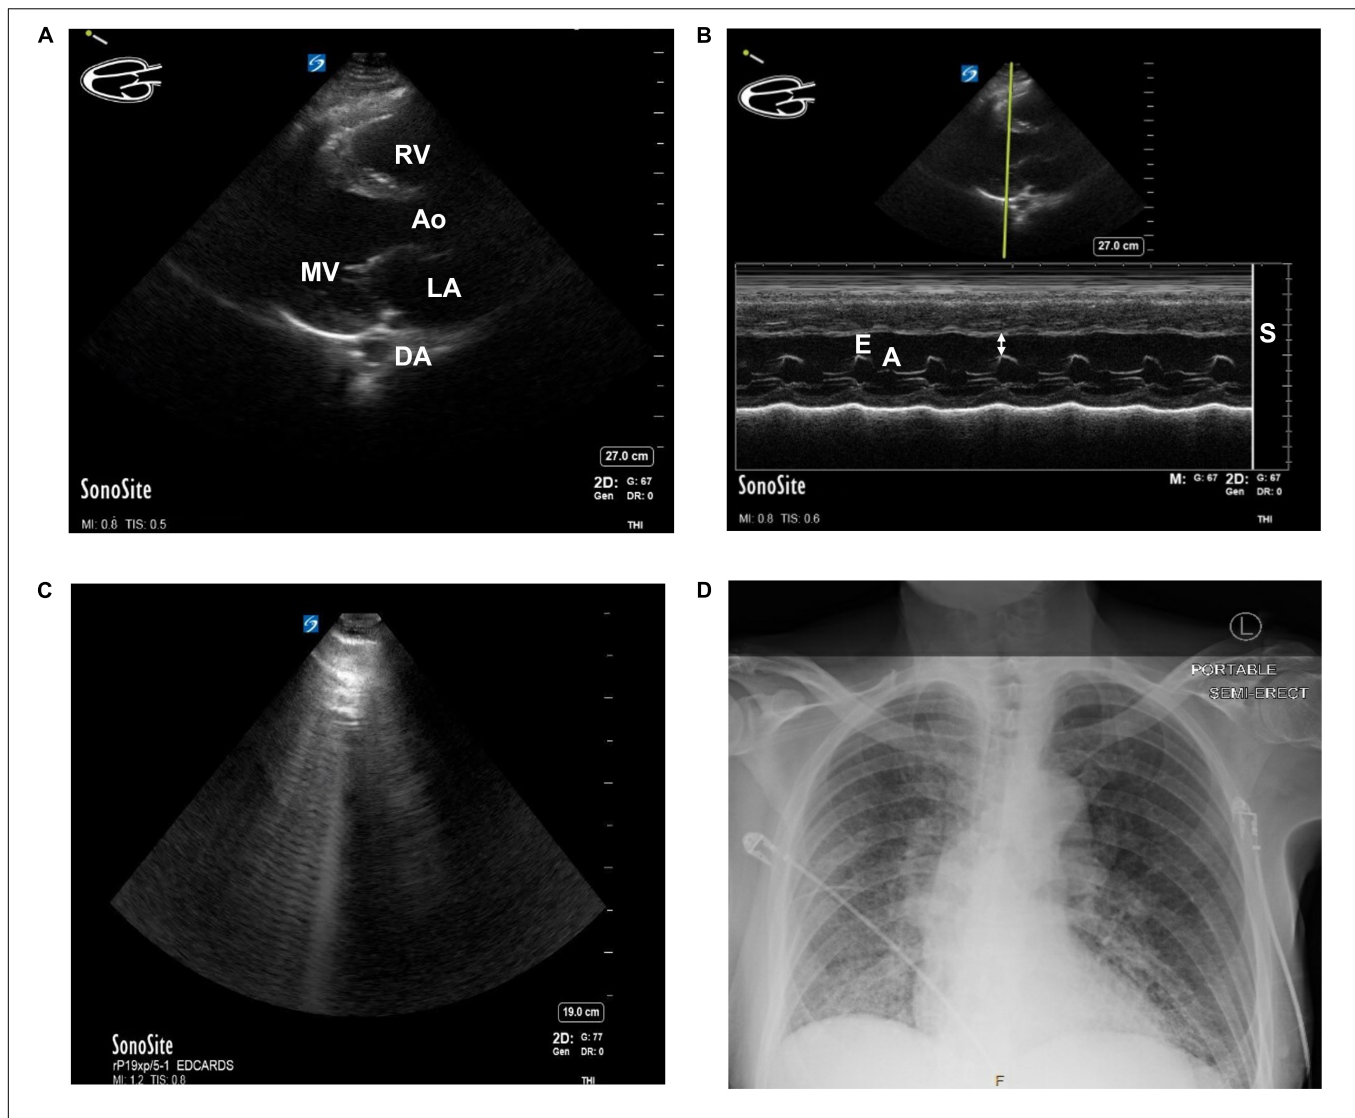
(A) Parasternal Long Axis (PLAX) view of the heart of a patient with known heart failure and diabetes using Point of Care Ultrasound (POCUS) imaging technique. MV, mitral valve. Ao, Aortic outflow. DA, descending aorta. LA, left atrium. RV, Right ventricle. (B) E-point Septal Separation (EPSS) calculation of the same patient with known heart failure and diabetes using POCUS. M-Mode doppler tracing. Estimated ejection fraction of 32%. Double arrow = EPSS. E = E wave. A = A wave. S = septum. (C) B-lines seen while performing cardiac ultrasound in a patient with COVID-19. A patient presented to the Emergency Department in acute hypoxic respiratory failure secondary to SARS-CoV-2 infection. The B-lines pattern seen above is indicative of lung pathology and, in the setting of SARS-CoV-2 infection, often correlates with ground-glass opacities on CT. (D) Chest x-ray of the same patient. Findings of bilateral ground-glass airspace disease. With no prior known hypercoagulable risk factors other than age and SARS-CoV-2 infection, this patient was found to have ground-glass opacities on CT and a new pulmonary embolism. Patient consent was obtained for publication and discussion of ultrasound and x-ray imaging.
